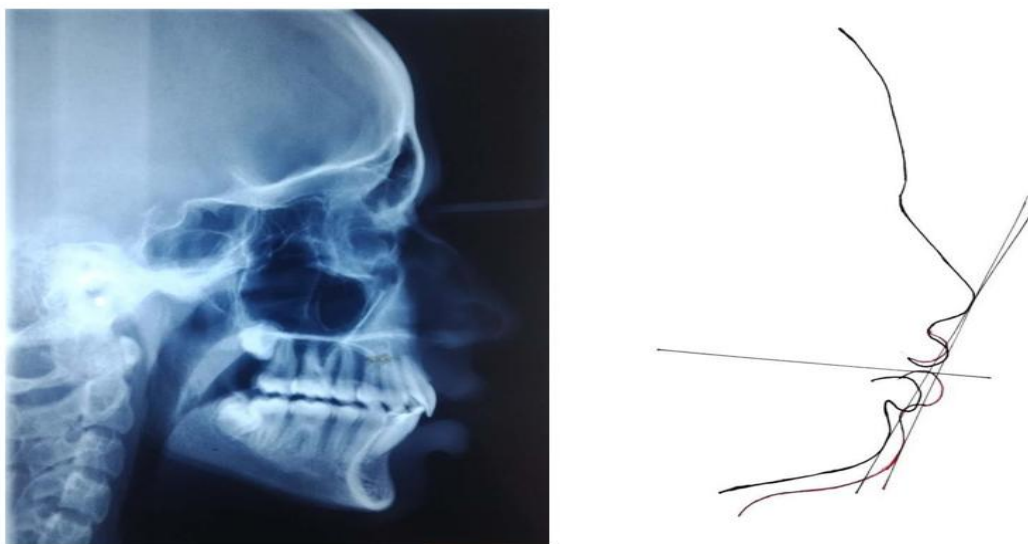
Posttreatment cephalographic image (a); overall superimposition of pretreatment (black color) and posttreatment (red color) cephalometric radiographs (b).
